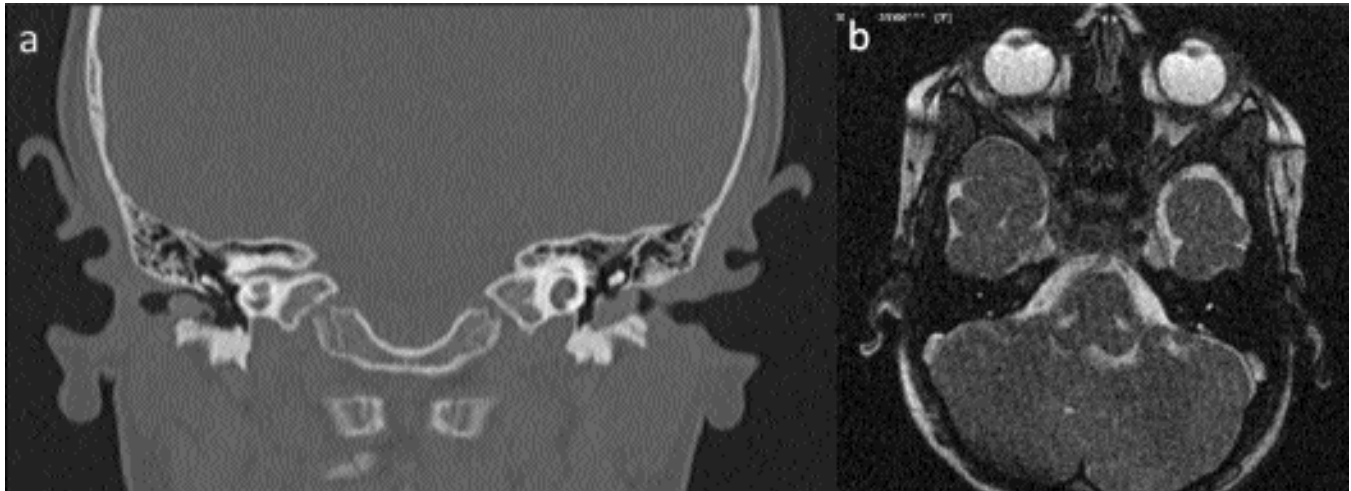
(a) CT scan revealed cystic cochleae with dilated vestibules bilaterally. Further, the modiolus could not be visualised, suggesting incomplete partitioning resulting in confluency between the middle and apical segments. (b) MRI showing intact cranial nerve VIII.
